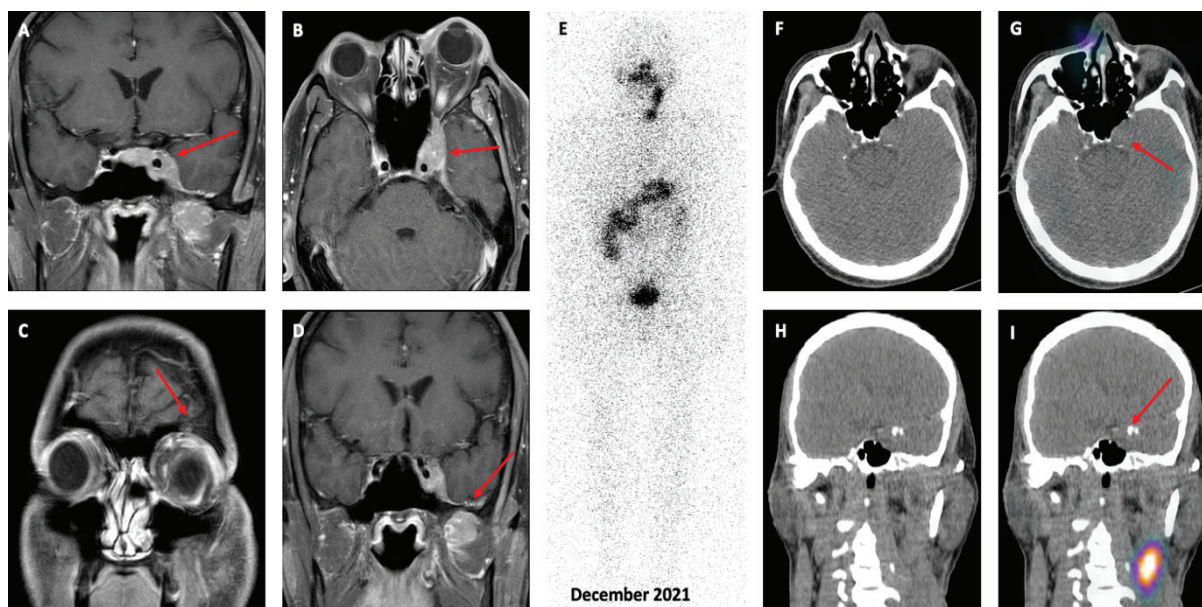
Four years after initial diagnosis, the patient developed progressive left-sided ptosis and ophthalmoplegia, corresponding to palsies of cranial nerves III, IV, and VI. Contrast-enhanced computed tomography (CT) and T1-weighted magnetic resonance imaging revealed an enhancing mass centered in the left cavernous sinus (A, B), measuring approximately 3.6 cm and extending into the orbital apex (C). Perineural spread was present along the mandibular and auriculotemporal nerves, with involvement of the deep lobe of the parotid gland, pterygopalatine fossa, and adjacent masticator space (D). Diagnostic iodine-131 whole-body scintigraphy (E) and SPECT/CT (F-I), performed following recombinant thyroid-stimulating hormone stimulation, demonstrated no abnormal uptake in the cavernous sinus region, confirming loss of iodine avidity.
